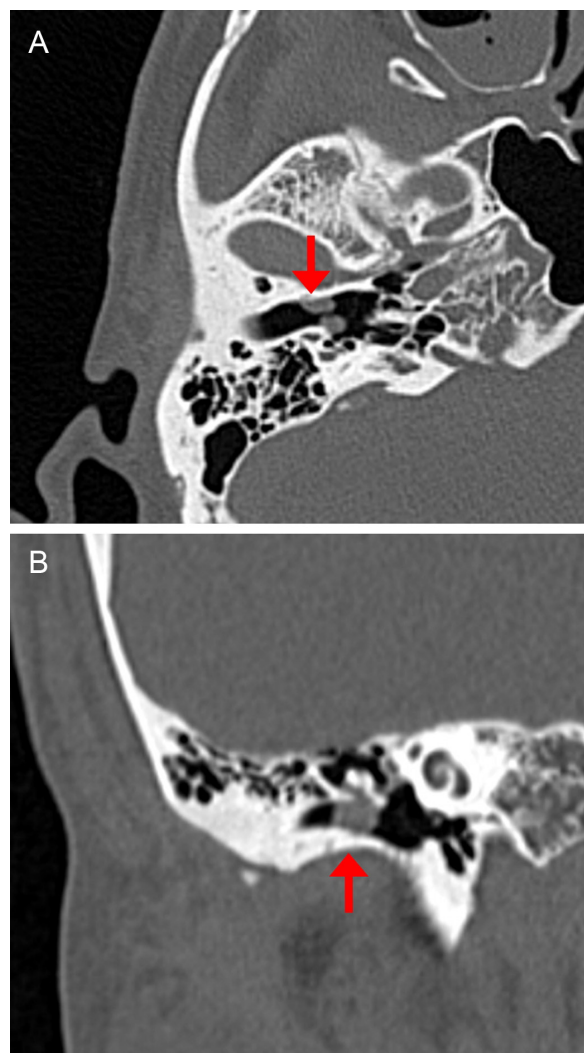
Computed tomography horizontal (2-A) and coronal (2-B) views of the right ear, showing an equidense mass in the right external auditory canal without bony destruction (arrow).
